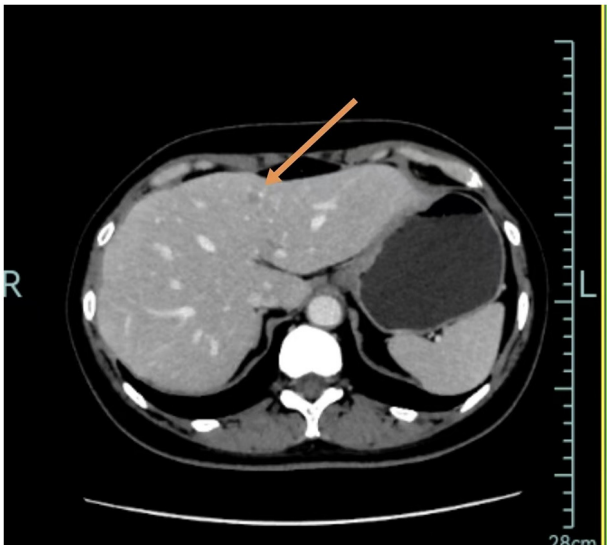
CT indicating that hepatic metastasis occurred 21 months after the initial surgery (arrow).
